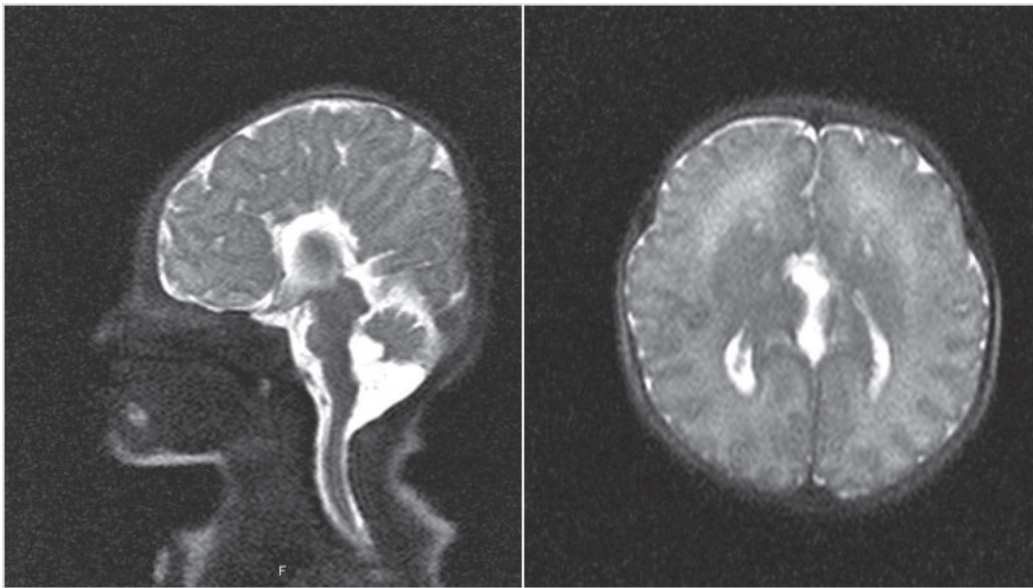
Brain MRI showing colpocephaly, agenesis of the corpus callosum and a posterior fossa cyst
